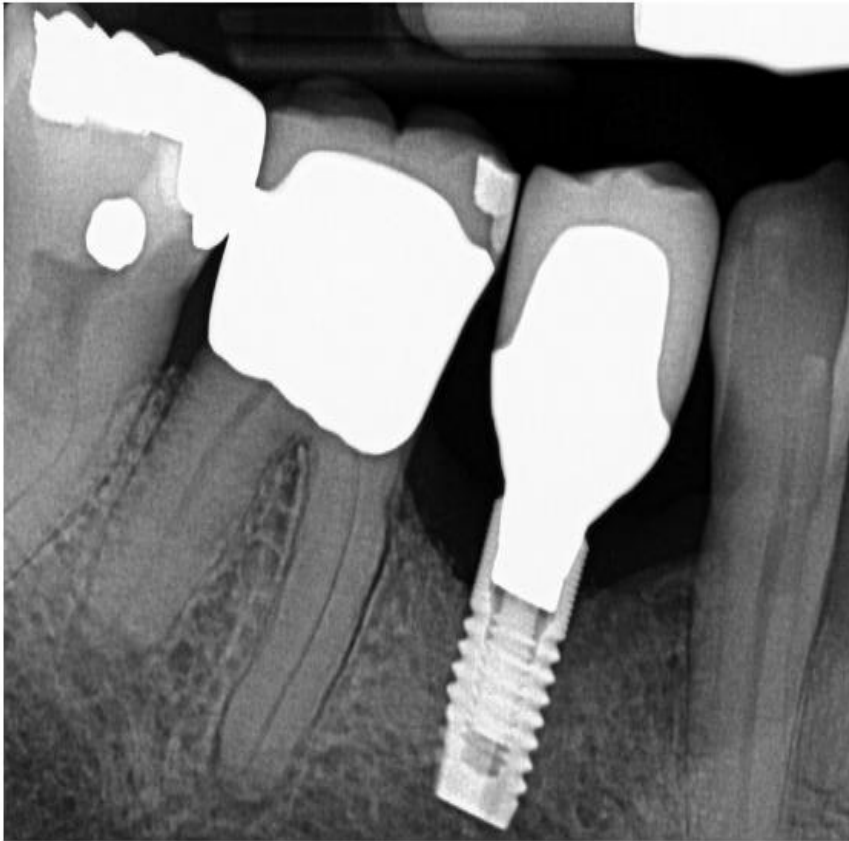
Peri-implantitis, Lack of Keratinized Tissue Etiology (mandibular right premolar) periapical radiograph: Alveolar crest levels appear diffuse. Horizontal bone loss pattern noted. Image provided by authors.
